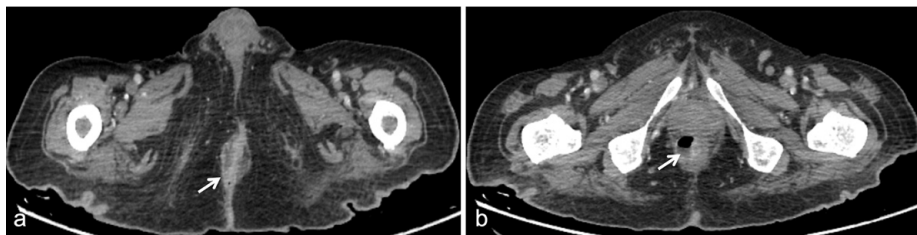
74 years old male admitted to the emergency room with pelvic pain. On contrast enhanced axial CT images a. perianal fistula and b. perianal abscess with air-fluid level is detected (arrows). CT: computed tomography
